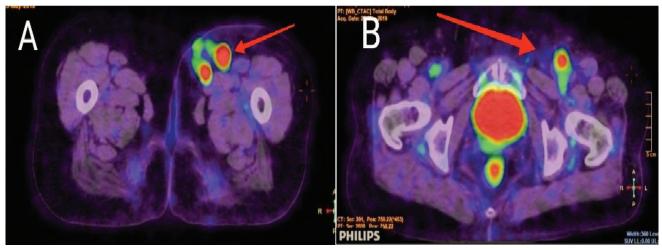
Axial images of 18F-FDG PET-CT scan, showing hypermetabolic left inguino-femoral lymph nodes (A, B).
